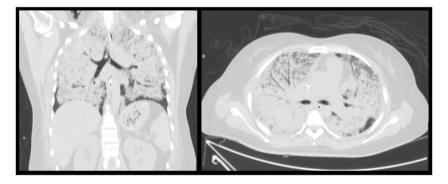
Chest CT axial and coronal axis. Showed a diffuse infiltrative opacification pattern compatible with diffuse alveolar hemorrhage.
